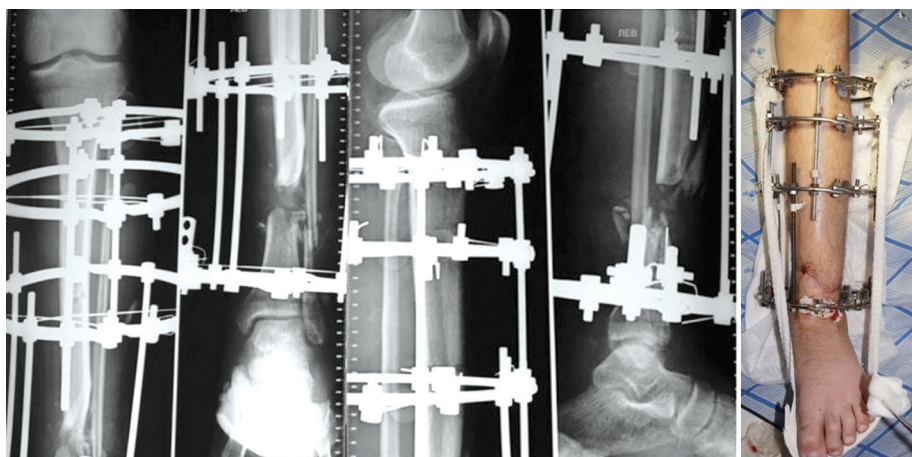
Radiographs of the tibia and the appearance of the limb before conversion to intramedullary osteosynthesis and tibial defect plasty (24 days after injury)
